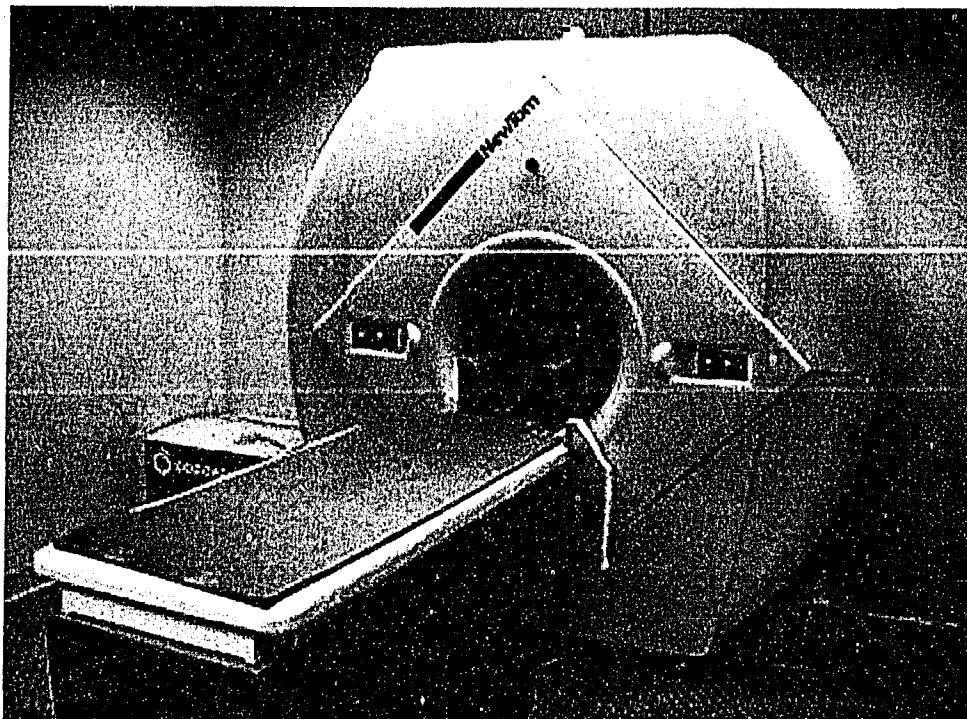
NewTom 9000 CBCT
